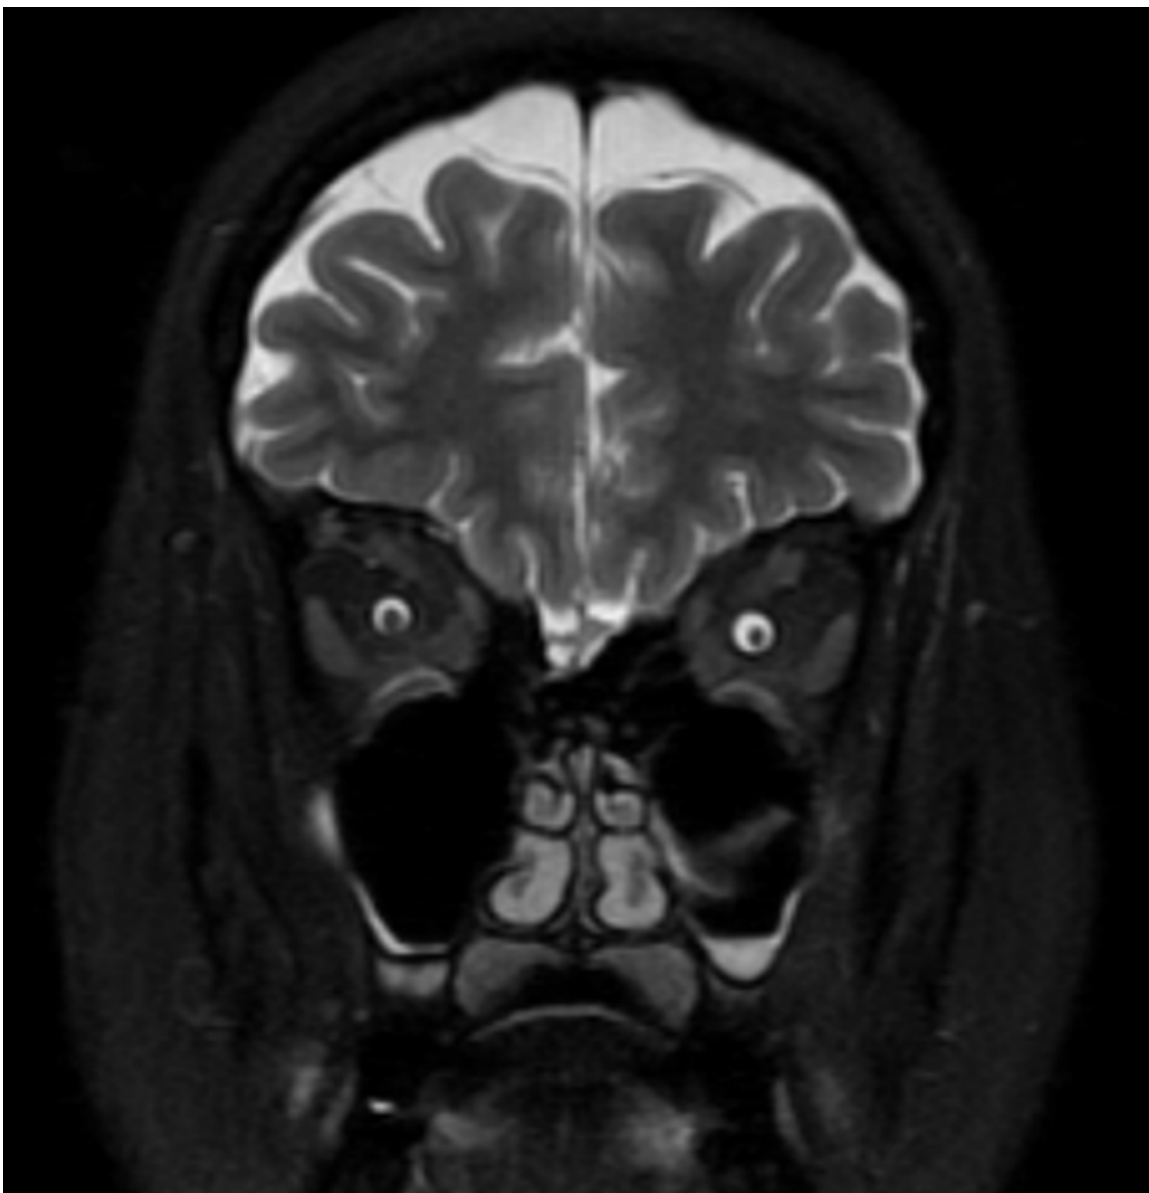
Coronal T2 MRI image, demonstrating excess of CSF surrounding the optic nerves
